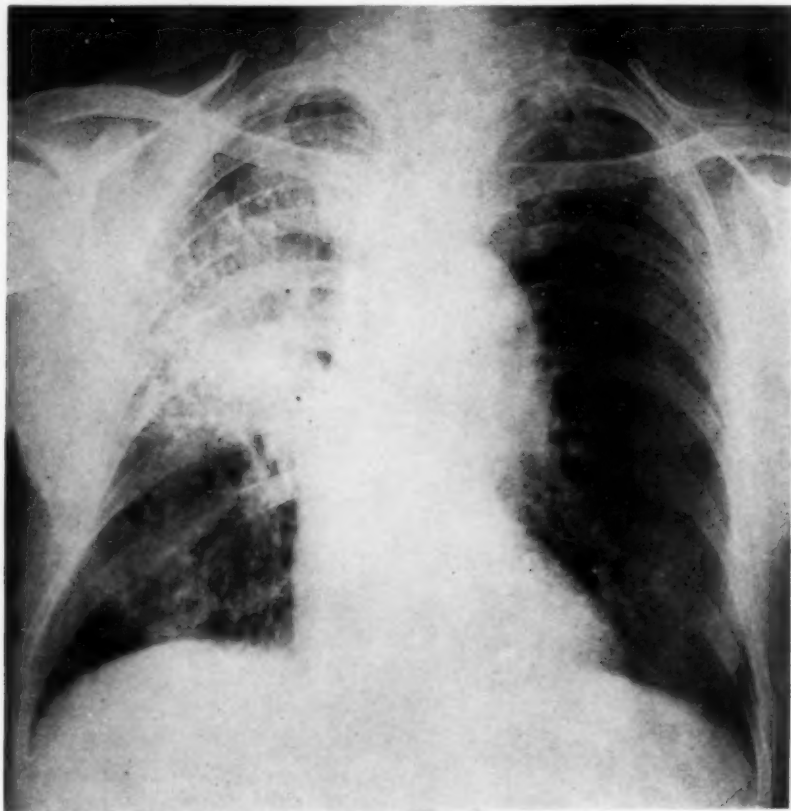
Later roentgenogram. Right midlung density, after seven weeks of potassium iodide therapy. Minimal regression has occurred since initial film. Some lipiodol remains in the right upper lobe from previous lipiodol study.
